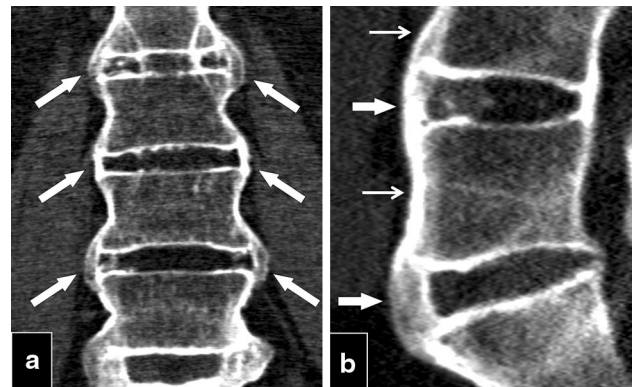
a, b 48-year-old man with primary ankylosing spondylitis. a Coronal multiplanar reformatted CT image of the thoraco-lumbar spine and b sagittal multiplanar reformatted CT image of the lumbosacral junction show symmetric and delicate syndesmophytes (*arrows* in a, e, b) and ossification of the anterior longitudinal ligament (*thin arrows* in b)
